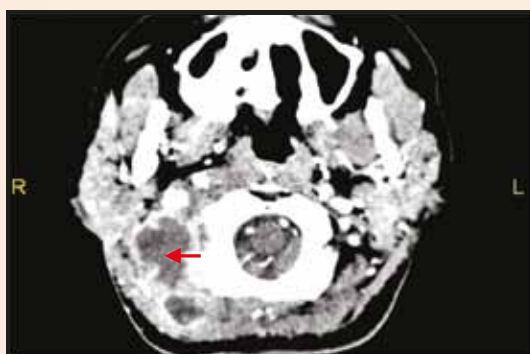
A cervical CT scan with IV contrast. An axial cut in a soft tissue window shows two deep hypodense collections in the neck with marginal enhancement deep to the SCM muscle that favor Bezold's abscesses.
